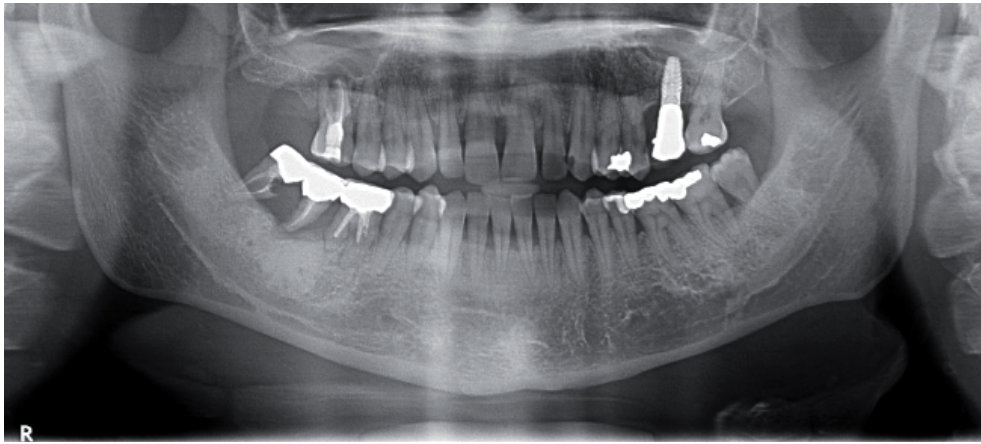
Orthopantomography showing the involved first right superior molar (1.6) with evident infection
